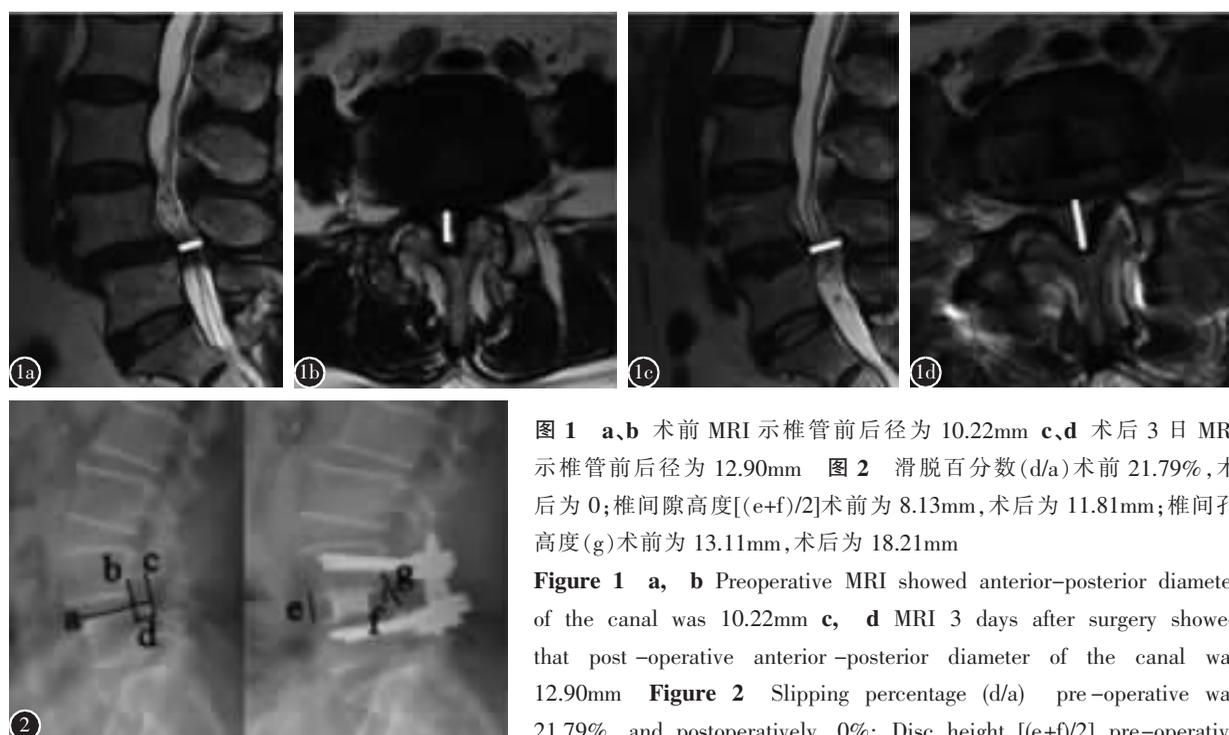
a、b 术前 MRI 示椎管前后径为 10.22mm c、d 术后 3 日 MRI 示椎管前后径为 12.90mm 图 2 滑脱百分数(d/a)术前 21.79%, 术后为 0;椎间隙高度[(e+f)/2]术前为 8.13mm, 术后为 11.81mm;椎间孔高度(g)术前为 13.11mm, 术后为 18.21mm
